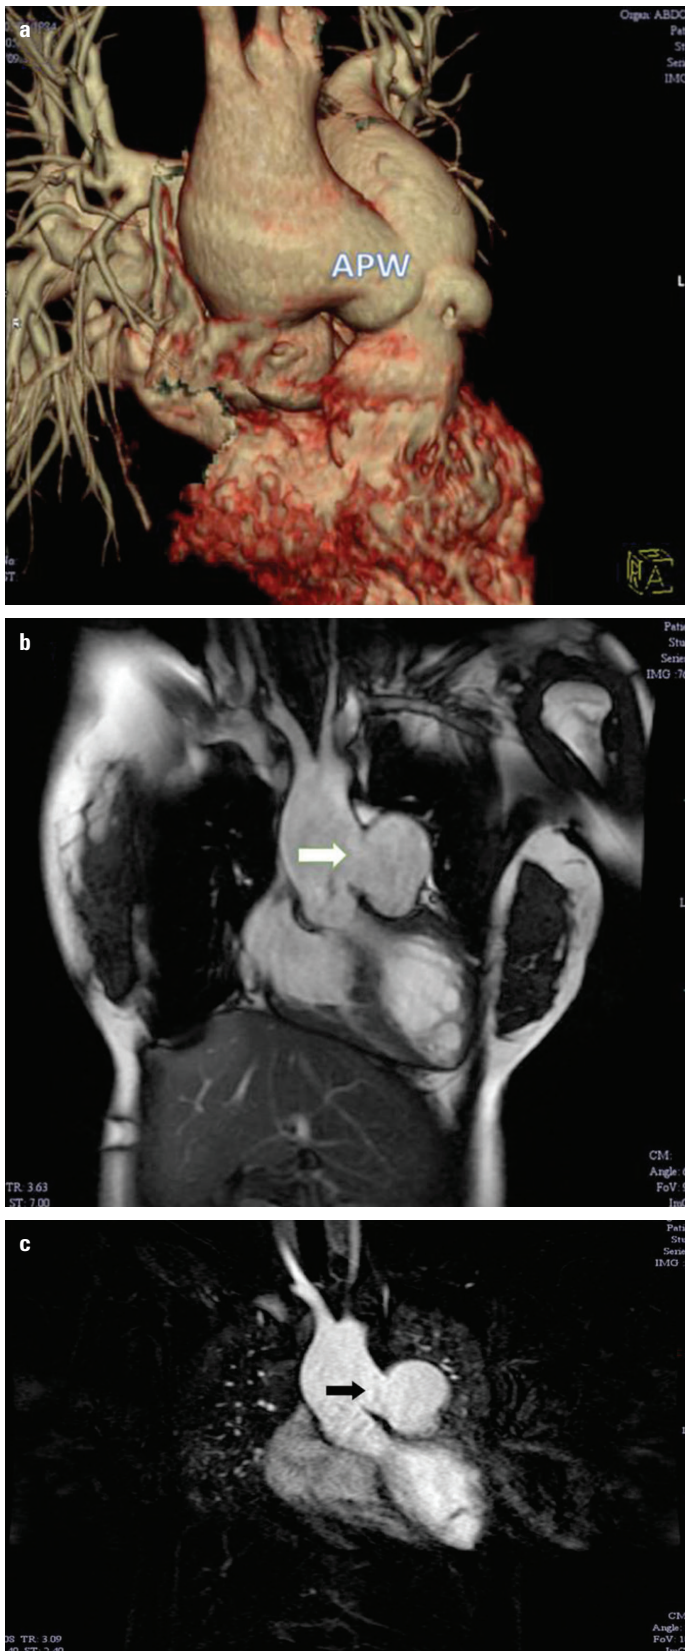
(a) Reconstructed MDCT images showing a large APW (arrow mark). (b) Cardiac magnetic resonance imaging (CMRI) showing the presence of a large APW (arrow mark; 3-cm defect). (c) CMRI flow study image
